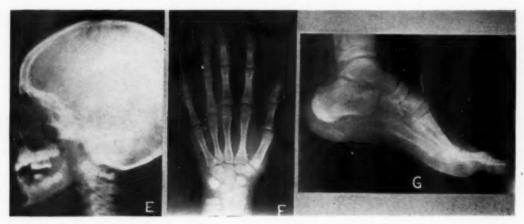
E, Profile x-ray of head negative. F, X-ray of wrist reveals normal osteogenetic development. G, X-ray of ankle reveals normal osteogenetic development.
